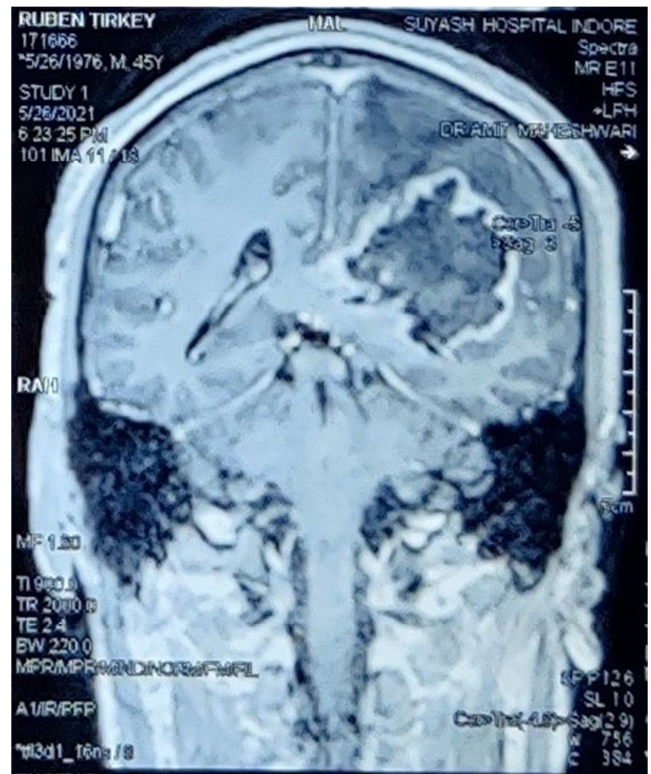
MRI brain coronal section.
